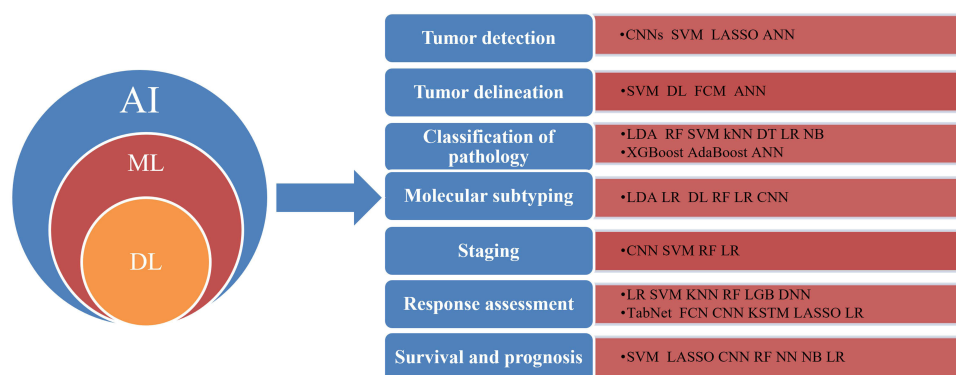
Application of PET/ CT-based ML in lung cancer. The relationship between AI, ML, and DL and the actual use of ML methods in the diagnosis and treatment of lung cancer.
